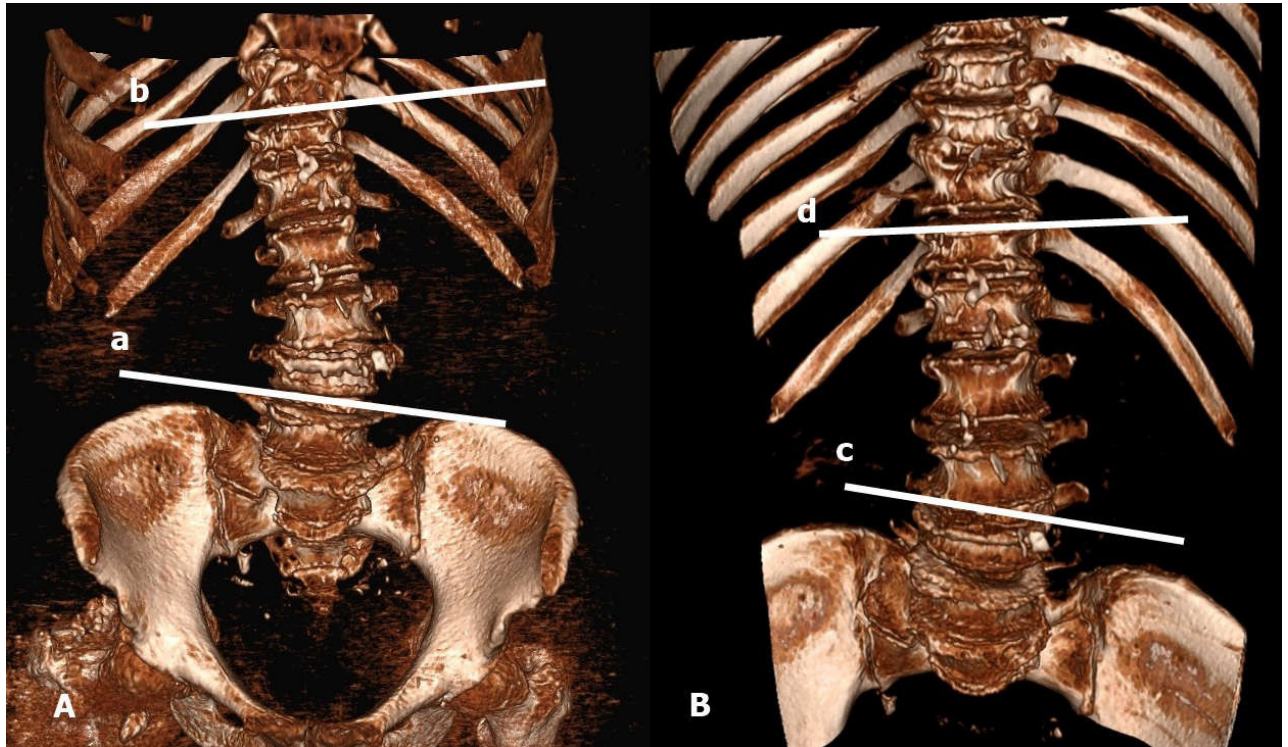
Three-dimensional reformat CT image showing collapse of the L3 vertebral corpus. (A) Preoperative Cobb angle (between lines a and b) of 18°, and (B) postoperative Cobb angle (between lines c and d) of 14°.
